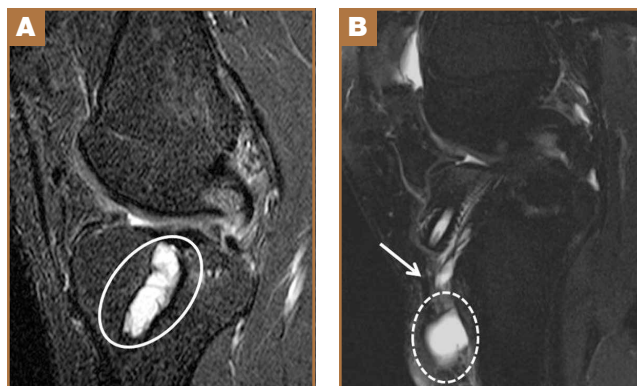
(A) Sagittal fluid-sensitive magnetic resonance imaging (MRI) shows high-signal cysts within tibial tunnel (circle). (B) Sagittal fluid-sensitive MRI (different patient) shows cystic structure anterior to tibial cortex (dashed circle) communicating with intraosseous tibial tunnel cyst (arrow), consistent with ganglion formation.
